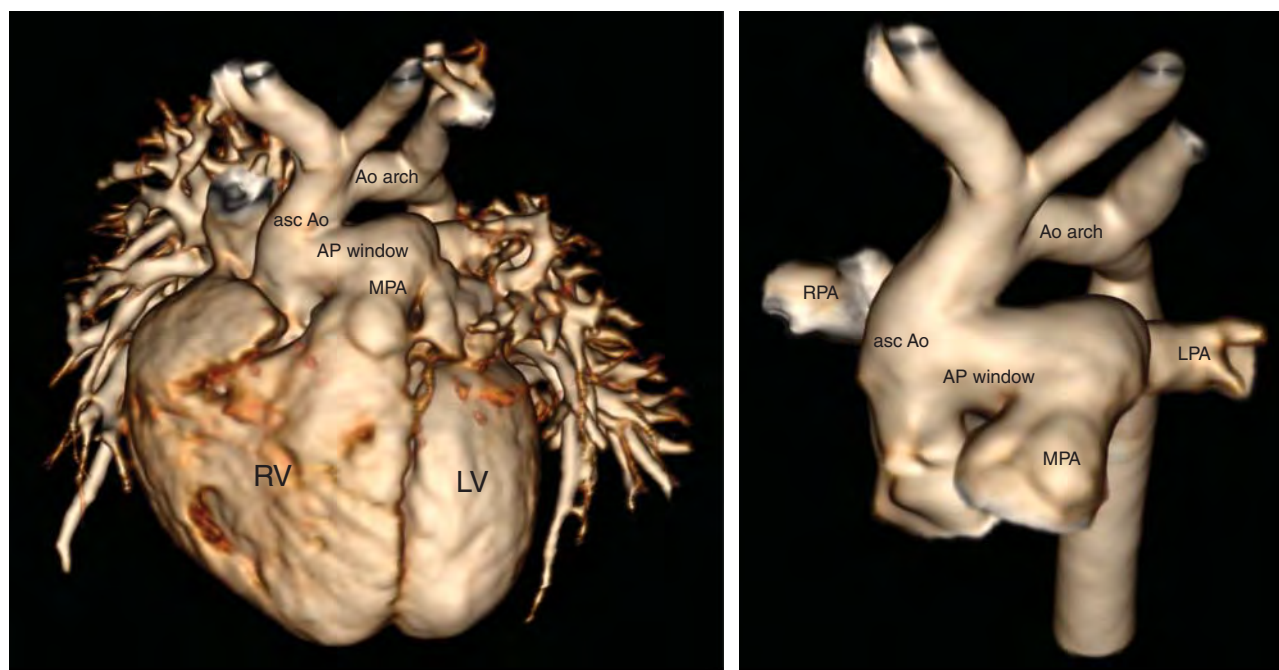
CT images demonstrating the location of aortopulmonary window (APW). Ao arch, aortic arch; AP, aortopulmonary; asc Ao, ascending aorta; LPA, left pulmonary artery; LV, left ventricle; MPA, main pulmonary artery; RPA, right pulmonary artery; RV, right ventricle.
